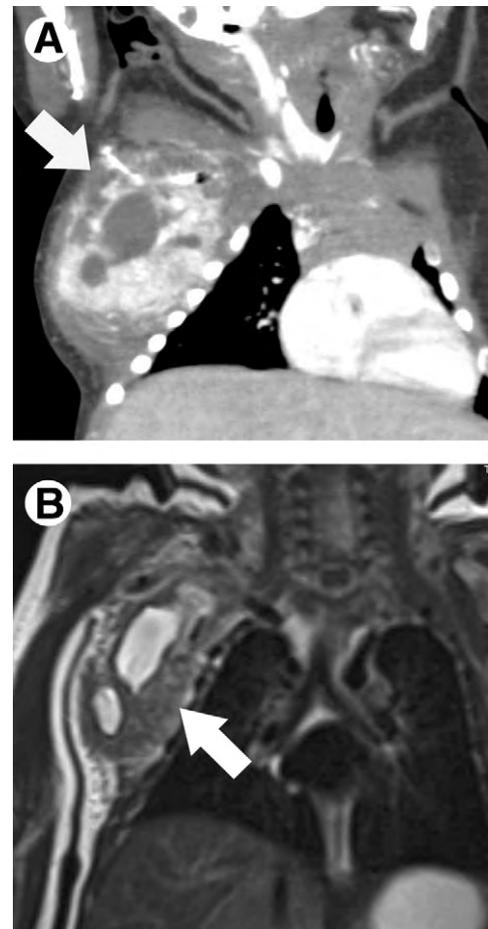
Kaposiform hemangioendothelioma in a 1-day-old female patient with a right chest mass. (A) Coronal reconstructed contrast-enhanced CT image reveals a lobulated enhancing mass with central necrosis in the chest wall (arrow). (B) Coronal T1-weighted MR image confirms a right chest wall mass (arrow) with intrinsic high signal centrally, suggesting internal hemorrhage.
